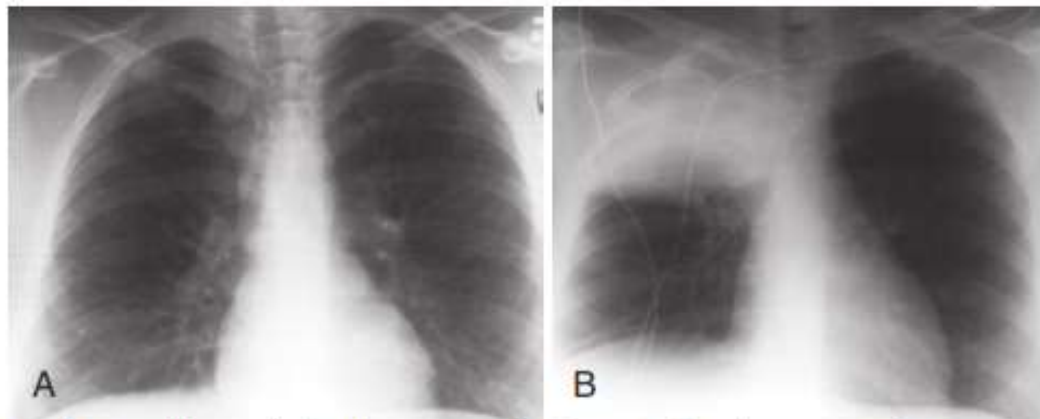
Chest radiographs before (A) and after (B) development of an acute, community-acquired, pneumococcal pneumonia. The patient is facing toward the reader. B, Consolidation of the right upper lobe of the lung is evidenced by the dense, whitish opacification of this lobe, which contrasts with the normal air (*black*) density of the remainder of the lung.
